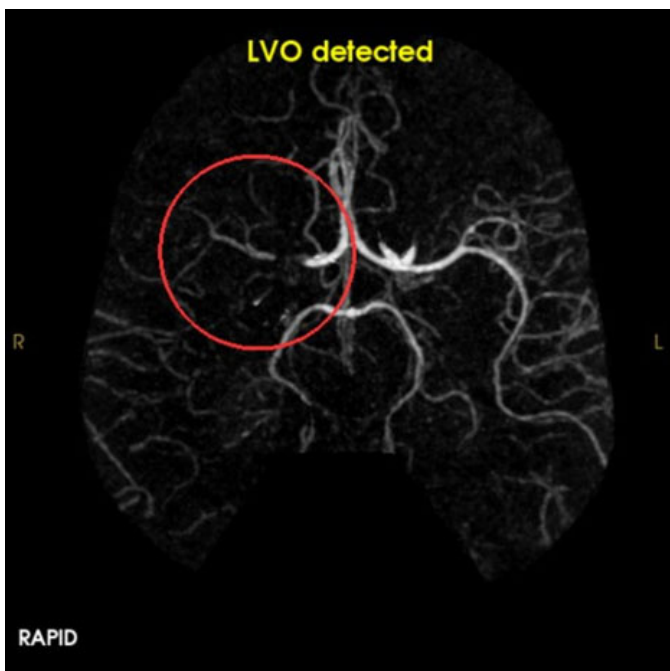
CT angiogram: Total occlusion of the right internal carotid artery commencing at the proximal segment with appearance concerning for dissection.
